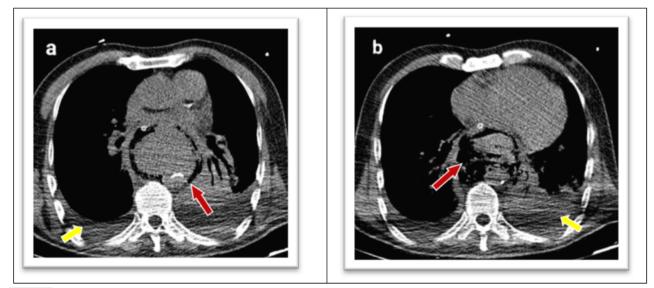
a, b Chest computed tomography scan without contrast (axial plane) showing soft tissue density surrounded by gas in the postmediastinum (red arrows) and pleural effusion on both sides (yellow arrows).
